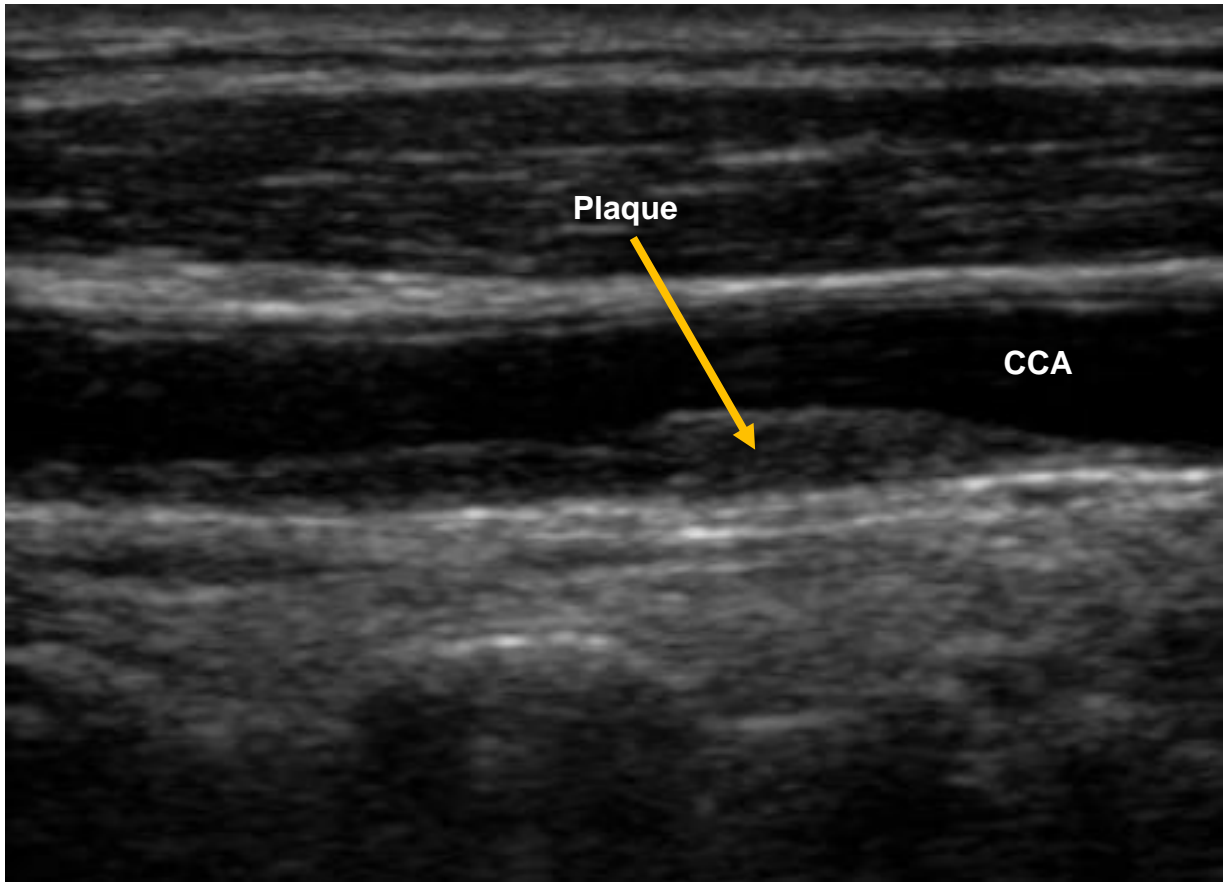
A longitudinal view of an ultrasound image of the common carotid artery showing the presence of plaque. (CCA: Common carotid artery).
